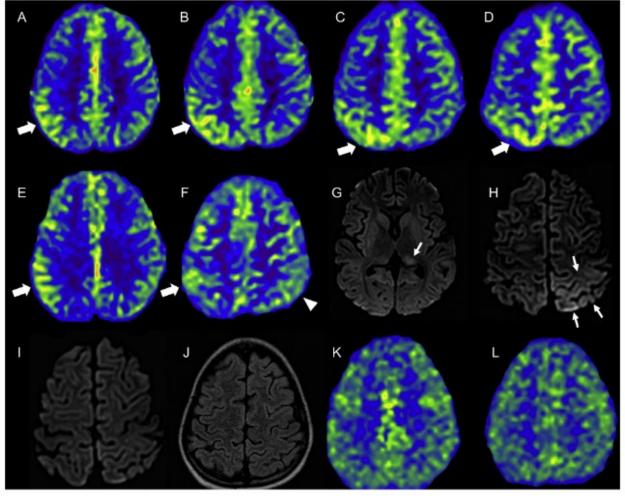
Imaging findings. (A-D) Brain magnetic resonance imaging (MRI) performed at admission. Axial arterial spin labeling (ASL) perfusion imaging shows increased signal in the right parietal lobe (thick arrows, A-D). (E-H) Brain MRI performed 1 month later. Axial ASL imaging shows areas of persistent increased perfusion in the right parietal lobe (thick arrows, E and F) and mild increased perfusion in the left parietal lobe when compared with the prior examination (arrowhead, F). Diffusion-weighted imaging (DWI) shows mild hyperintensity in the left parietal cortex and in the ipsilateral thalamic pulvinar (thin arrows, G and H) suggestive of peri-ictal restricted diffusivity (apparent diffusion coefficient maps, not shown, demonstrated hypointense signal in the corresponding areas). (I-L) Brain MRI performed at 6 months, after bortezomib treatment. Axial DWI (I) and fluid-attenuated inversion recovery (J) images do not show abnormalities or sequelae in the previous areas of increased perfusion or restricted diffusivity. ASL imaging shows symmetric normal perfusion of the cerebral hemispheres.
